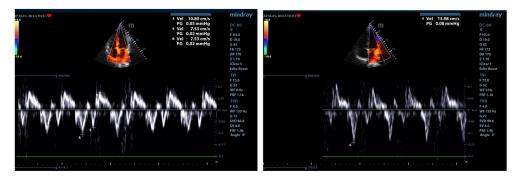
Figure nr. a.2.6. Myocardial tissue Doppler, normal findings. Left: septal measurements ( $e'_s = 10.8 \text{ cm/s}$ ,  $a'_s = 7.53 \text{ cm/s}$ ;  $e'_s / a'_s > 1$ ). Right: lateral measurements;  $e'_1 = 13.98 \text{ cm/s}$ .
